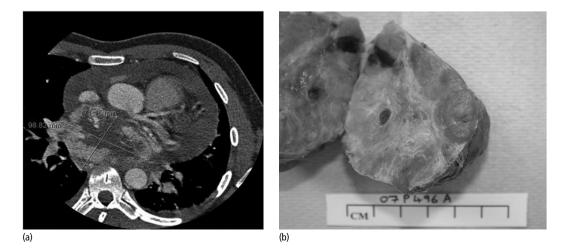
(a) Computed tomography scan showing a mediastinal paraganglioma. (b) Resected mediastinal paraganglioma.
